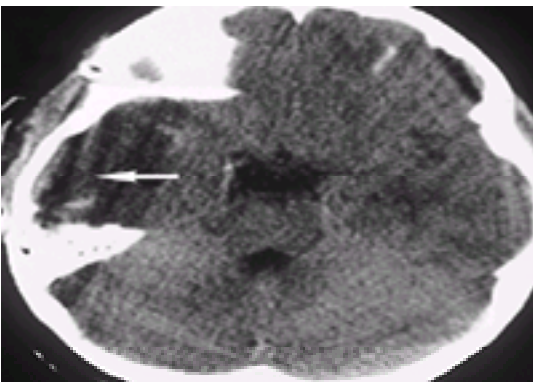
Cerebral contusion. This head computed tomography (CT) scan was performed on a 6-year-old boy who was found unresponsive and apneic after being a passenger in a high-speed motor vehicle collision. The *arrow* indicates a large area of hypodense nonhemorrhagic contusion in the right temporal lobe.
